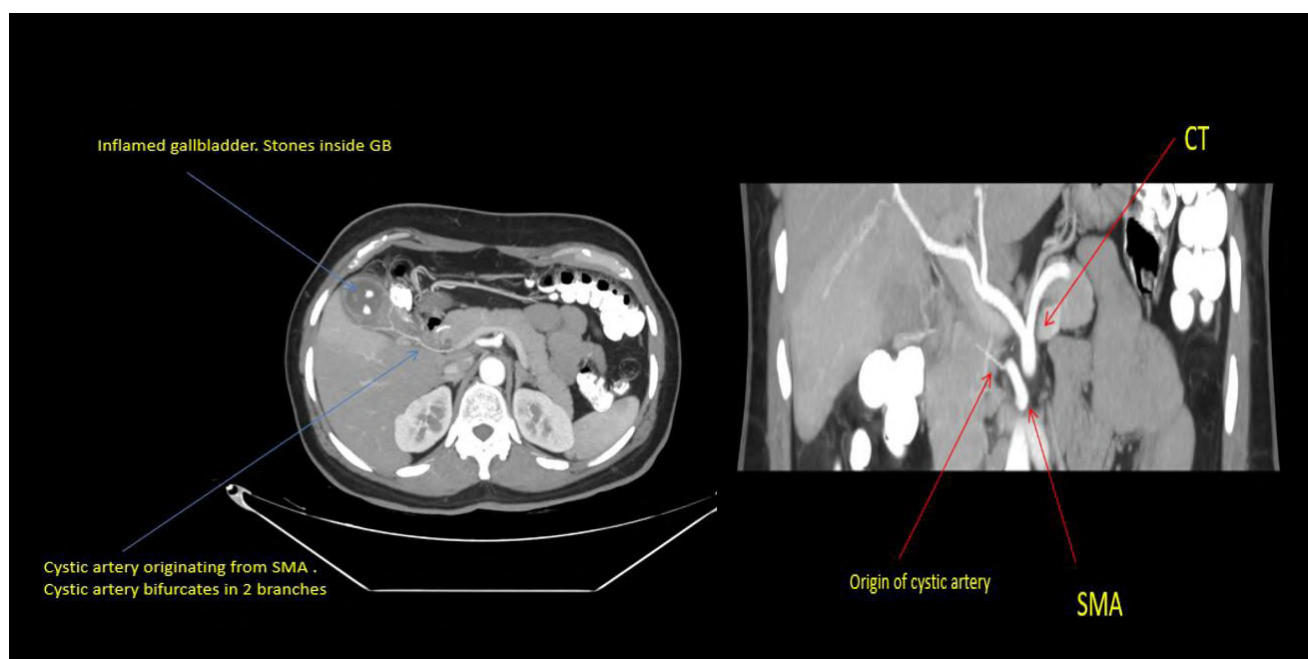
Left: CT scan which shows the inflammation of the gallbladder and the stones inside the gallbladder and the course of cystic artery. Right: CT scan which shows the origin of the cystic artery from the superior mesenteric artery. SMA: superior mesenteric artery, CT: celiac trunk.
